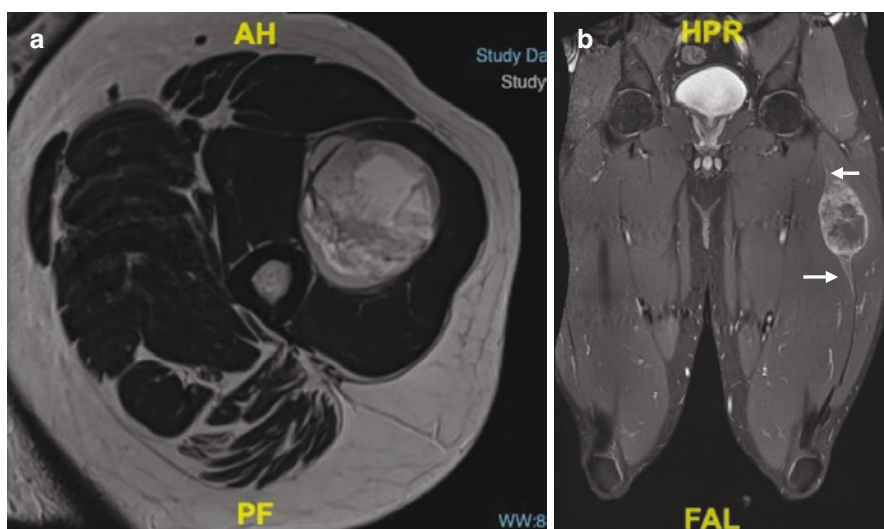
(a) T2-weighted axial MRI image of a myxoid liposarcoma involving the vastus lateralis muscle. (b) T1-weighted fat-saturated coronal post-gadolinium contrast image demonstrating a “tail” of interfacial oedema (arrow)
